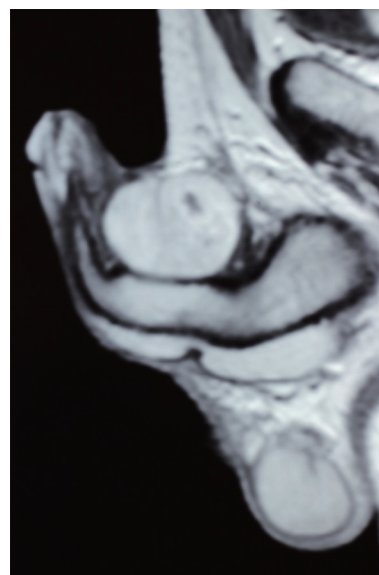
Magnetic resonance imaging scan showing the interphase or separation between the tumor and the corpus cavernosum.
